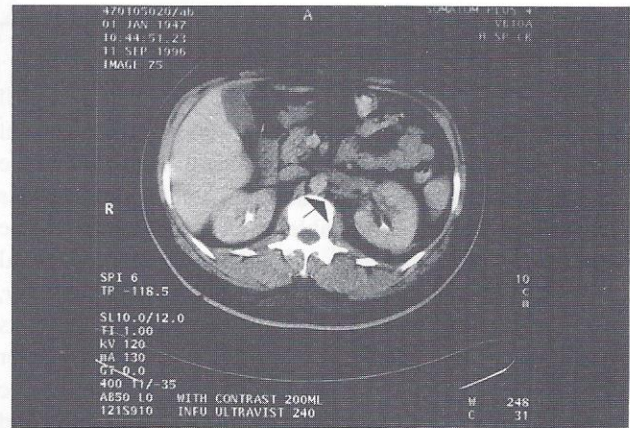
CT abdomen with IV contrast (ultravist) showing swollen left kidney with left RVT (arrow).
